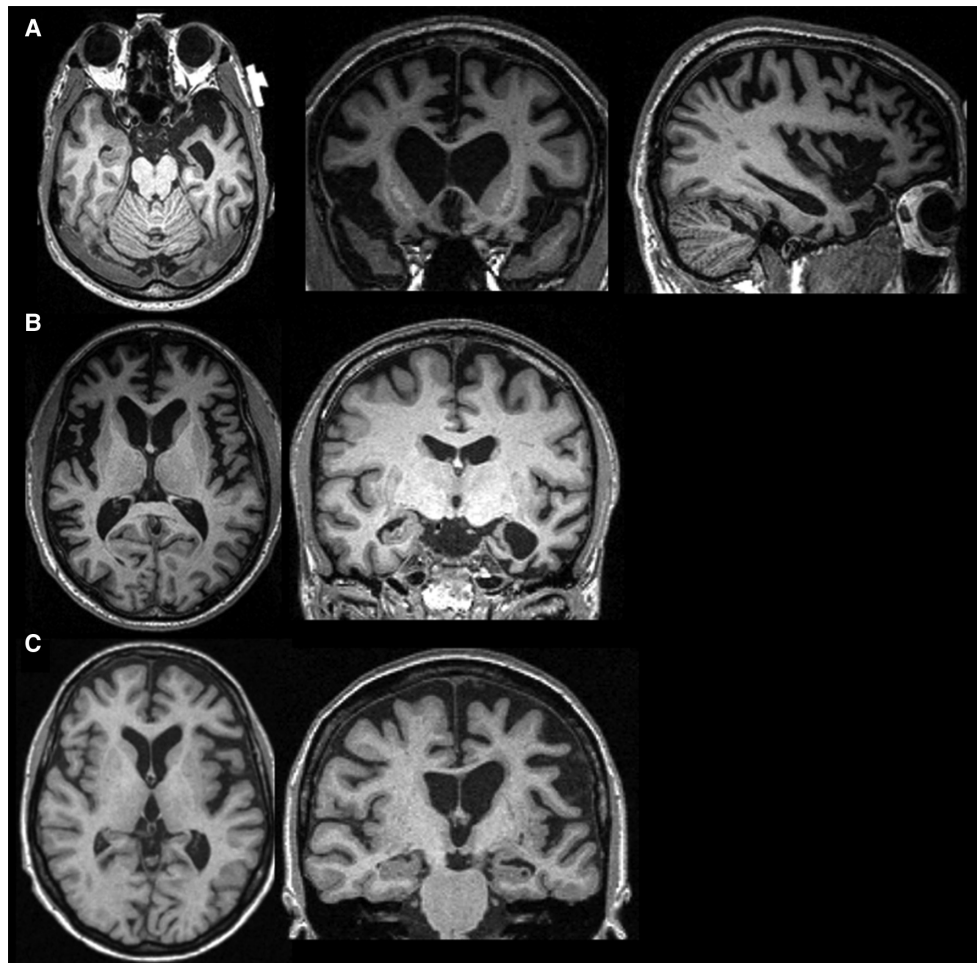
Magnetic resonance imaging (MRI) in three variants of frontotemporal dementia (FTD). T1-weighted brain MRIs in behavioral variant FTD (bvFTD) (A), semantic variant primary progressive aphasia (svPPA) (B), and nonfluent variant (nfvPPA) (C). (A) A 55-year-old woman with a 4-year history of bvFTD with a score of 27/30 on the mini-mental status examination (MMSE) showing an axial, coronal, and sagittal (*right* side) MRI with significant bilateral (*right* more than *left*) frontal atrophy. (B) A 61-year-old man with svPPA showing symptoms for 1.5 years that included forgetting the names of friends and the names and knowledge of common objects. He also showed difficulty with planning, multitasking, and marked rigidity of daily routines. MRI shows severe left temporal pole atrophy. (C) A 74-year-old man with 2 years of progressive word-finding difficulty, slowed and effortful speech, phonemic paraphasias, and speech apraxia. MRI shows left insular and perisylvian atrophy consistent with nfvPPA. Orientation of coronal and axial MRIs are radiologic. (Images courtesy of Dr. David Perry.)
